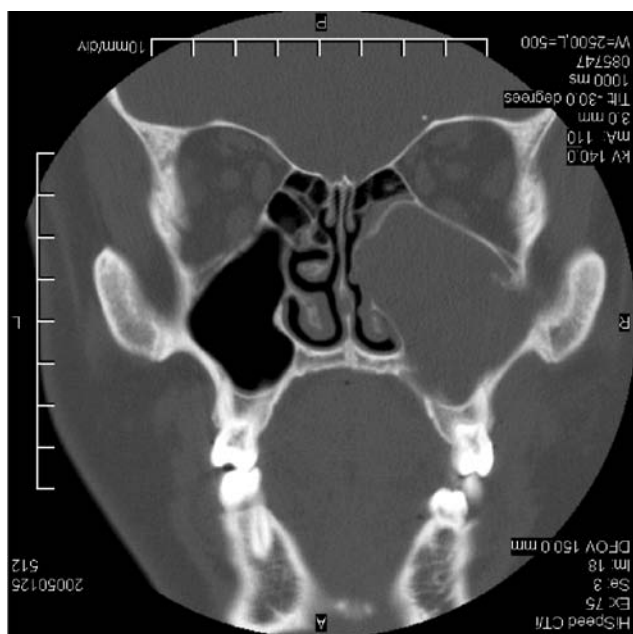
CT scan showing infiltration into, and expansion of, the left maxillary sinus by an odontogenic keratocyst.
